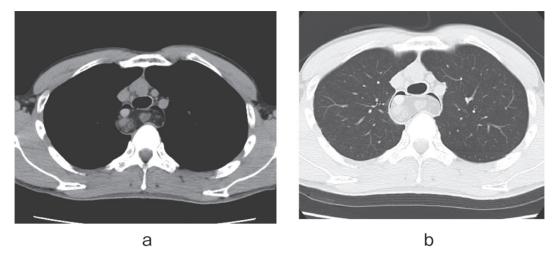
Computed tomography: a) mediastinal window and b) lung window
